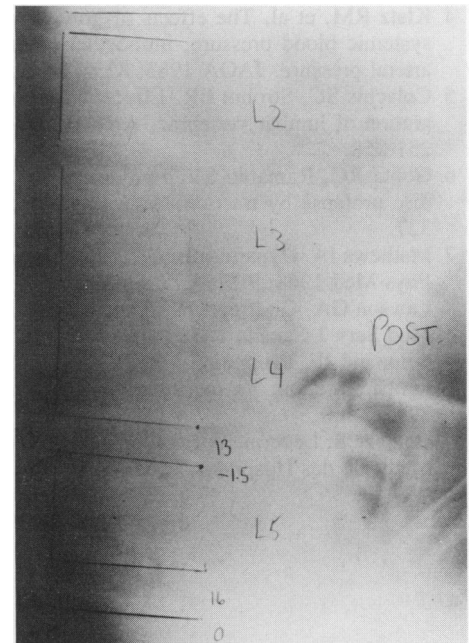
Patient #3. Post-Inversion radiograph.
